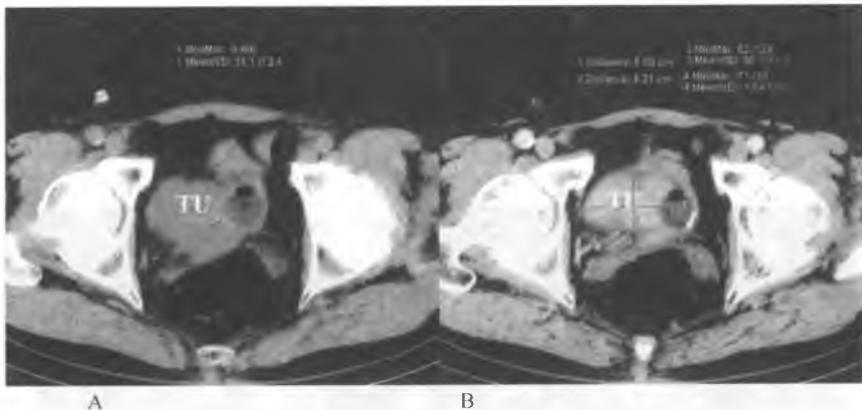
Axial CT section of the urine bladder reveals the solid, inhomogeneous pathological mass representing a bladder tumor. The enhanced CT section reveals a strong tumor contrast enhancement from 31 up to 88 HU – B (TU – tumor)
